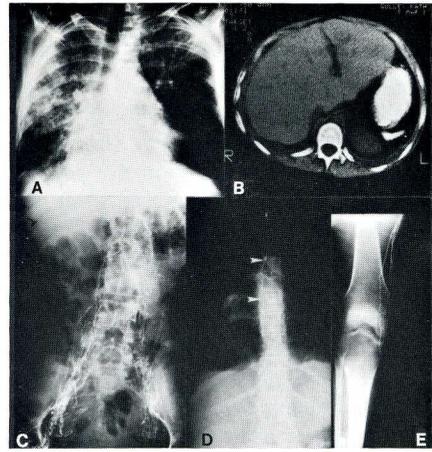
Chest x-ray (A), abdominal computed tomography (B), pedal lymphangiography (C-E), in a 24-year-old woman with recurrent pulmonary infection and protein-losing enteropathy. Note progressive lung fibrosis (A), absence of the spleen (B), involution of paraaortic lymph nodes with "dysplastic" retroperitoneal lymphatics (C), a normal thoracic duct (arrowheads-D), and intact peripheral lymph trunks (E). (Modified from *Lymphology* 18 (1985) 31) (15)
